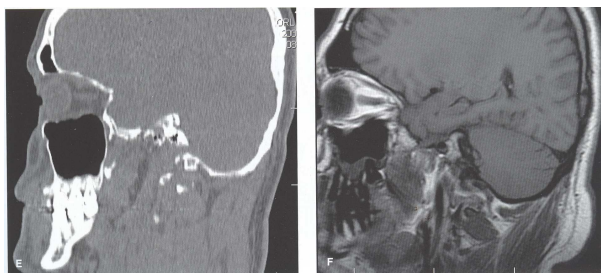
Comparison of CT and MR images [6]
